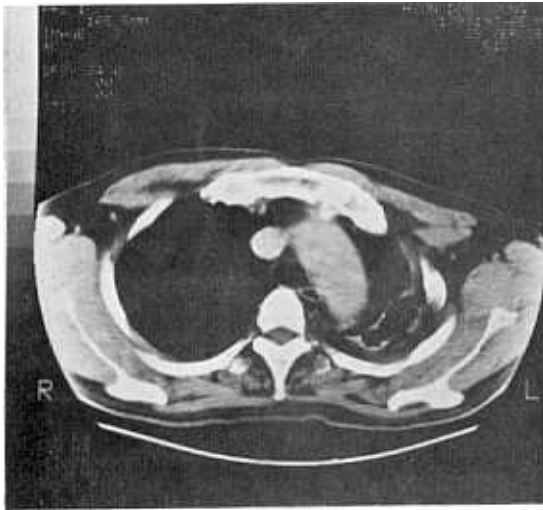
Chest CT scan reveals a large empyema space noted on the lateral position of left pleural cavity with calcifications along its pleural rim.
